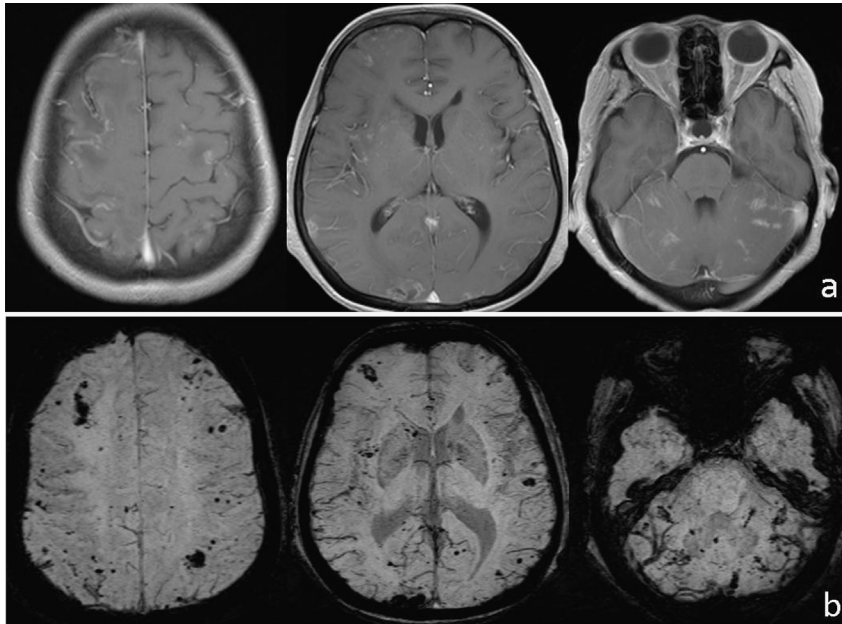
Follow-up contrast enhancement MRI (26th day) showed majorities of the lesions have been resolved, except for micro-hemorrhages.
